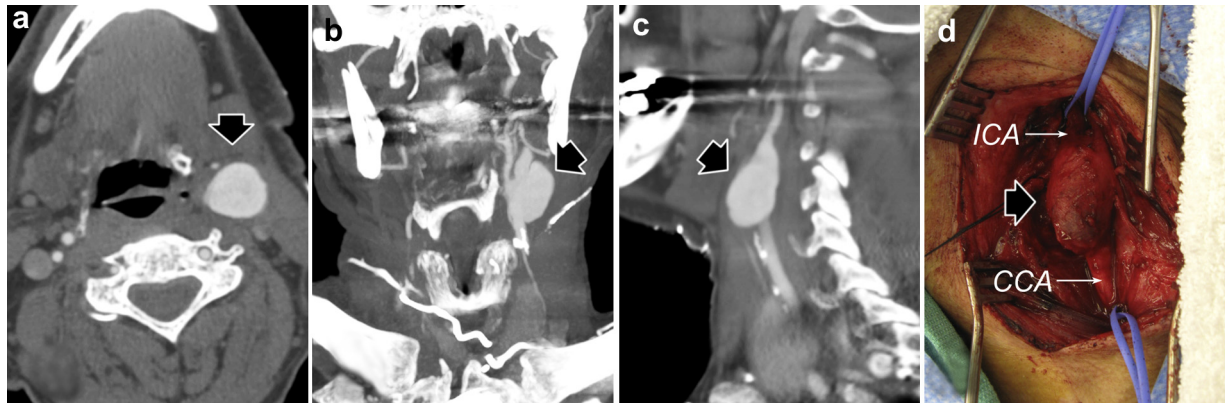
Carotid patch pseudoaneurysm. a, Axial computed tomography (CT) image. b, Coronal CT image demonstrating lobular superior extension (*arrow*). c, Sagittal CT image. d, Operative dissection from same patient showing common (CCA) and internal carotid (ICA) arteries with large small intestinal submucosa (SIS) patch pseudoaneurysm.
